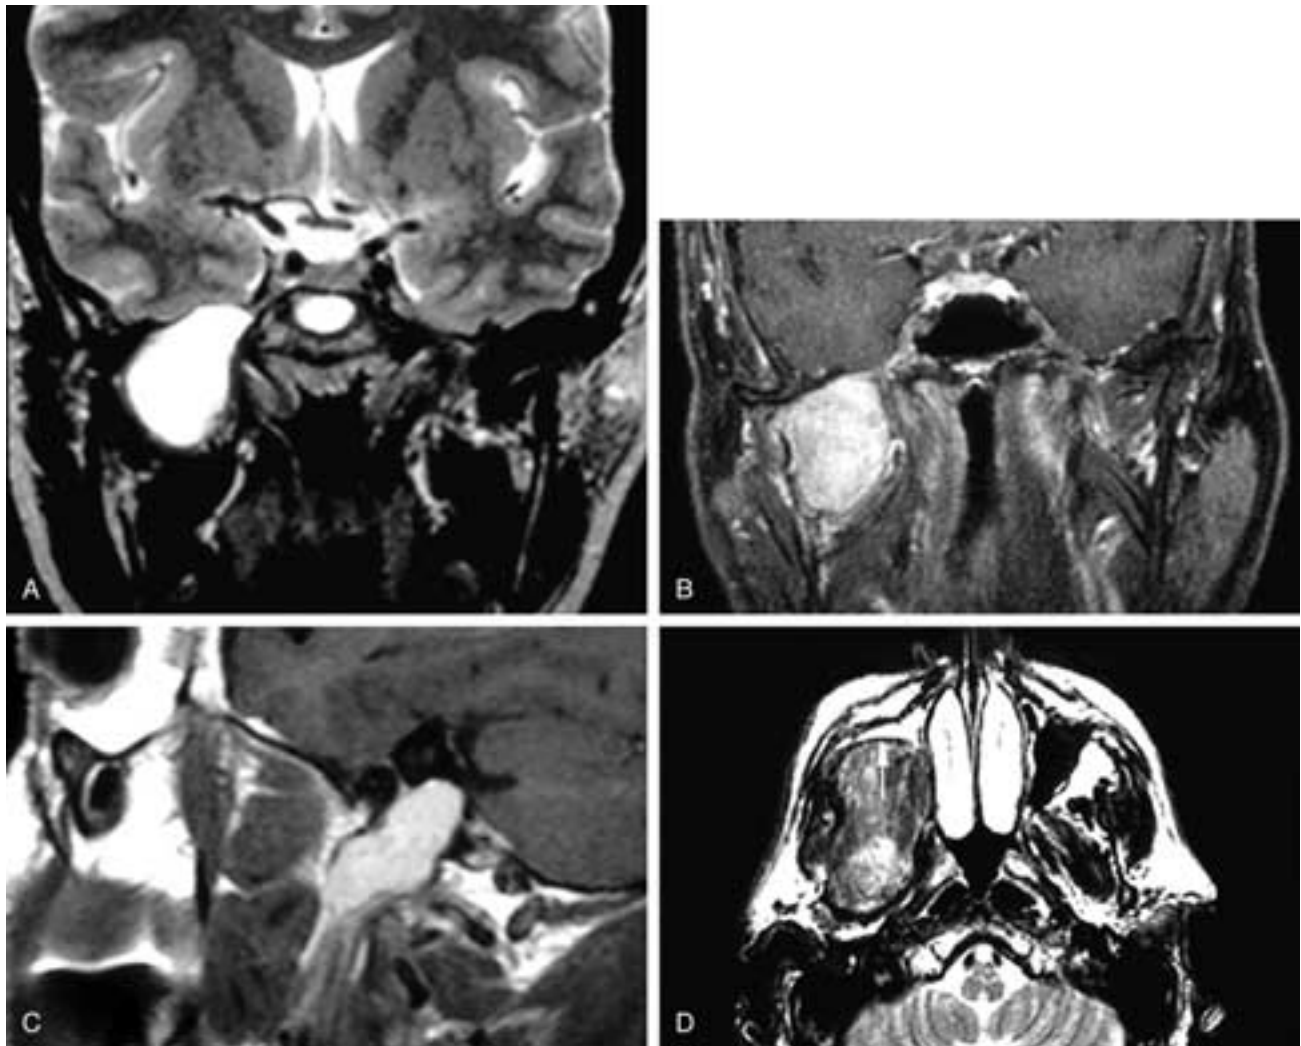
Coronal T2-weighted MR image (A) shows a high signal intensity mass within a smoothly widened right foramen ovale. This schwannoma extends both toward the cavernous sinus and down below the skull base into the masticator space. Although on coronal images such masses appear to lie directly above the parapharyngeal space, such schwannomas extend along the third division of the trigeminal nerve into the masticator space. Coronal T1-weighted, fat-suppressed, contrast-enhanced MR image (B) shows a schwannoma of V₃. The tumor extends from the smoothly widened foramen ovale down into the medial mandibular ramus, displacing the pterygoid muscles medially. Sagittal T1-weighted, fat-suppressed, contrast-enhanced MR image (C) shows a schwannoma of V₃ extending down into the masticator space. Axial T2-weighted MR image (D) shows a huge schwannoma of V₃ that extends through a smoothly widened foramen ovale down into the masticator space, where it has expanded the medial aspect of this space, filled the infratemporal fossa, and remodeled the posterior right antral wall forward (*arrow*).
